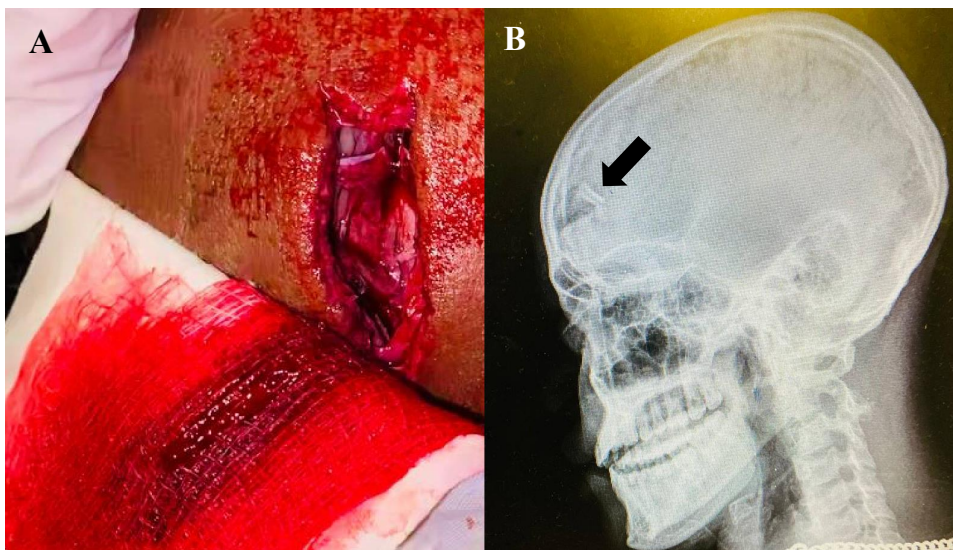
Compound depressed skull fracture. (A) Compound DSF of the right frontal bone with the depressed fragment visible underneath the scalp wound. (B) Lateral skull x-ray of the patient showing the fracture (arrow). Photos: Tsegazeab Lacke.
